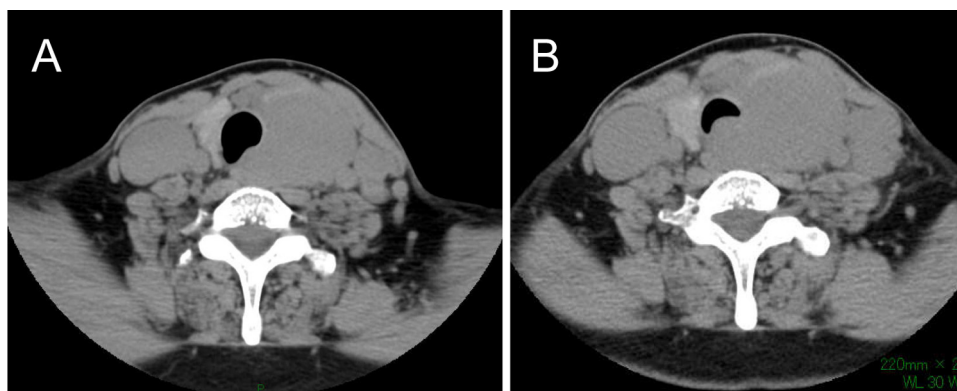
Enhanced computed tomography (CT) revealed progressive enlargement of the left lobe, which had caused severe compression of the trachea compared to the CT scan 1 week before.
